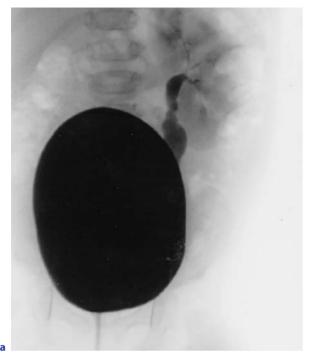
a Patient with right multicystic kidney and left intrarenal reflux. b Ultrasonography shows development of ureter dilatation after surgery (*cursors*). c Patient also developed subcutaneous abscess at wound site (*cursors*)
